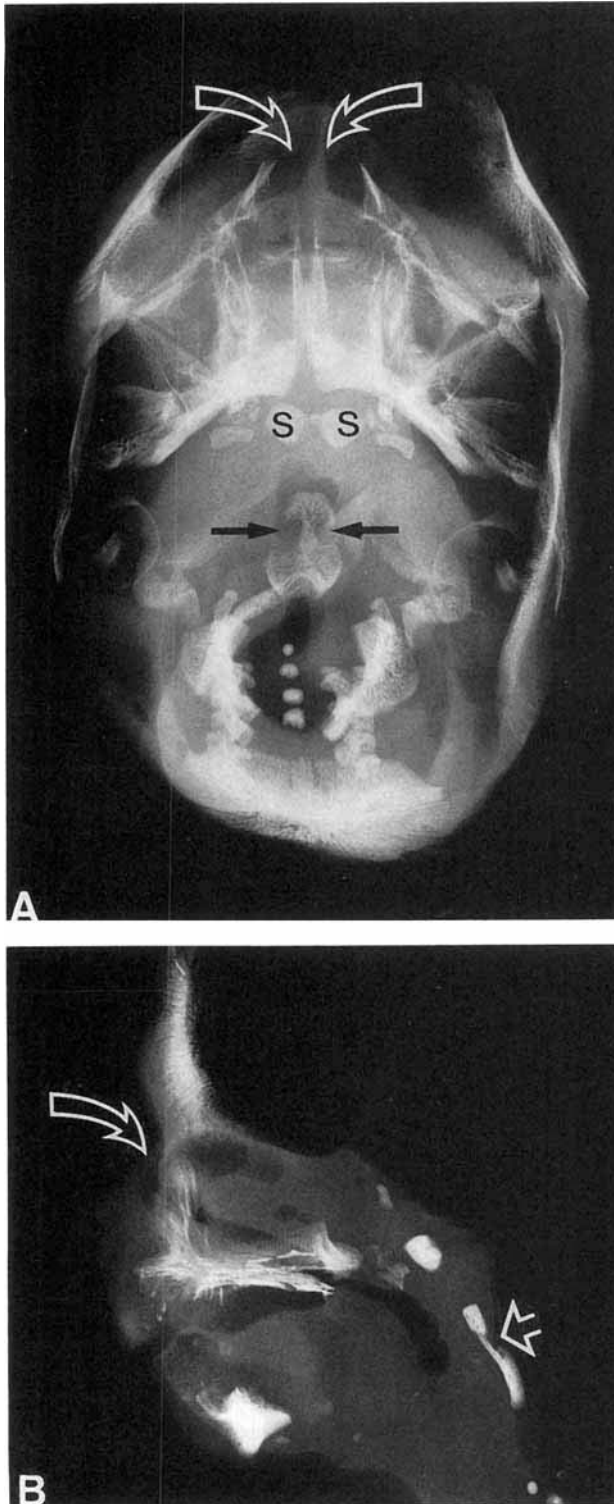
Radiographs of cranial base, including mandible from a human fetus with trisomy 18, 19 weeks of gestational age. A: Horizontal view. Note bilateral notching of basilar part of occipital bone (black arrows), the bilateral ossification centers (s) of postsphenoid bone component, and agenesis of nasal bones in the field indicated (white arrows) ($\times 2$). B: Lateral view of midsagittal segment of cranial base, constituting part of the upper axial skeleton. Note malformation of the basilar part of the occipital bone (straight arrow), and agenesis of nasal bones in the field indicated (curved arrow) ($\times 2$).
